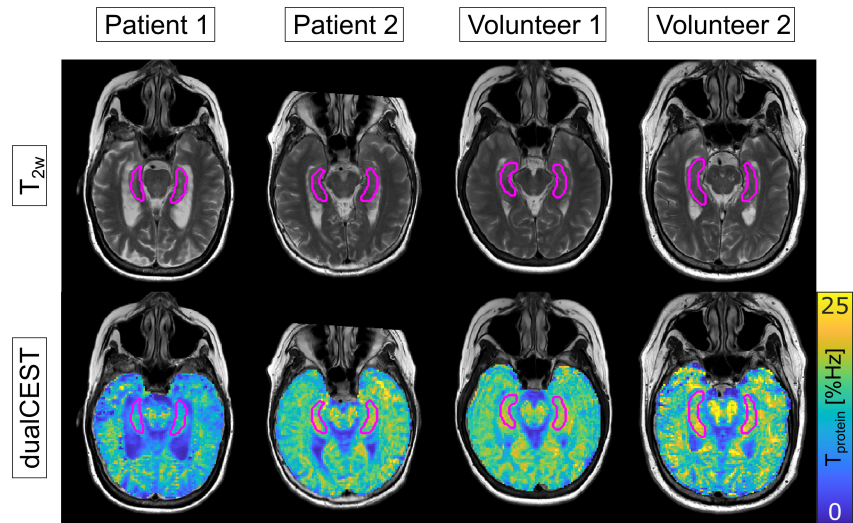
Representative slices of the dualCEST-MRI examinations of two Alzheimer’s patients and two healthy volunteers. For statistical analysis, regions of interest in the hippocampus (magenta border) were defined on the anatomical T_2 -weighted images.
